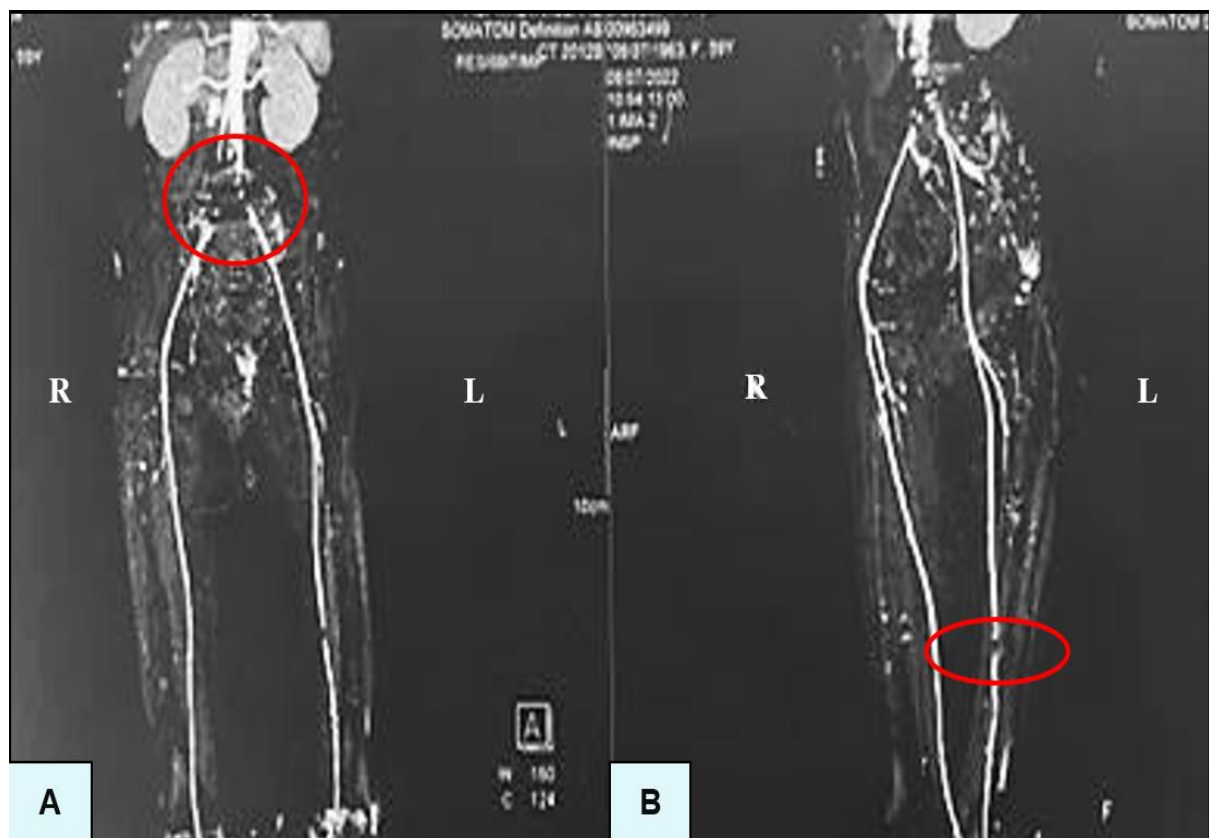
Computed tomography angiography of the abdominal aorta and lower limbs. (A) Aorto-bi-iliac occlusion with distal reconstitution of the external and internal iliac arteries. (B) Absence of opacification of the left anterior and posterior tibial arteries.
